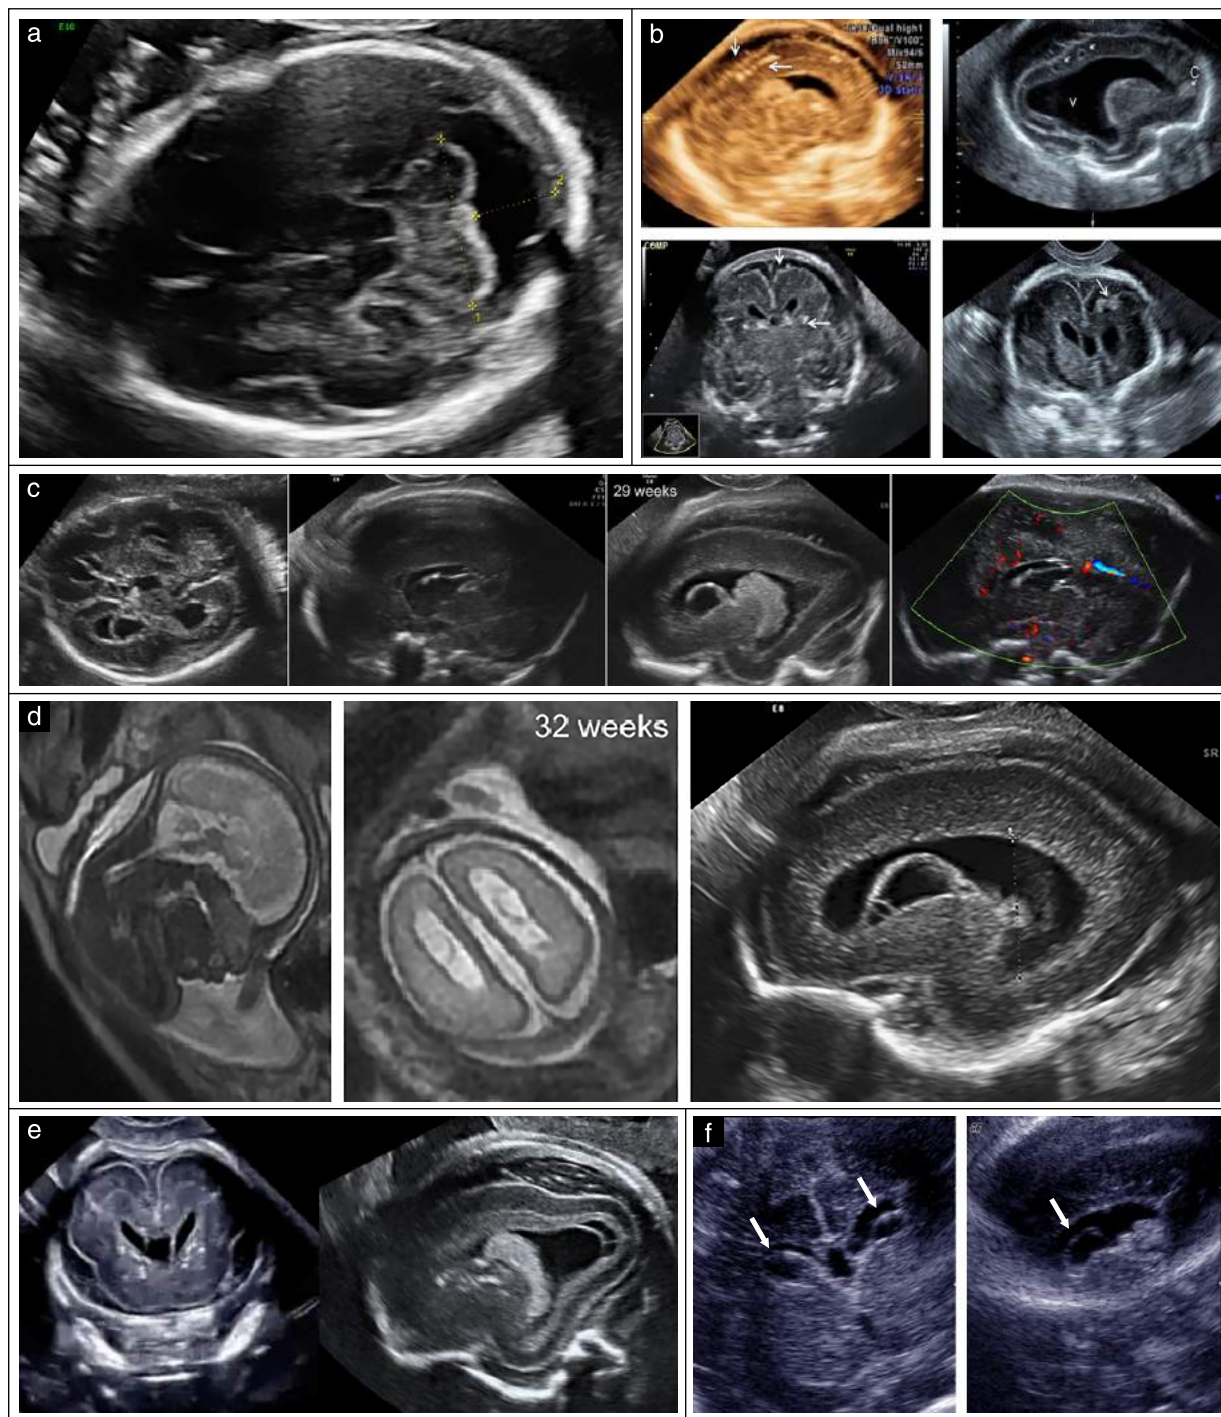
Ultrasonographic and MRI cranial features typical of CMV infection vary, and include: megacisterna magna (a), intracranial calcifications (b), ventriculomegaly, germinolytic cysts, agenesis of corpus callosum and intraventricular adhesions (c,d), periventricular cystic changes (c,f), lissencephaly (d), cerebral calcifications and periventricular cysts (e) and subependymal cysts (f).
